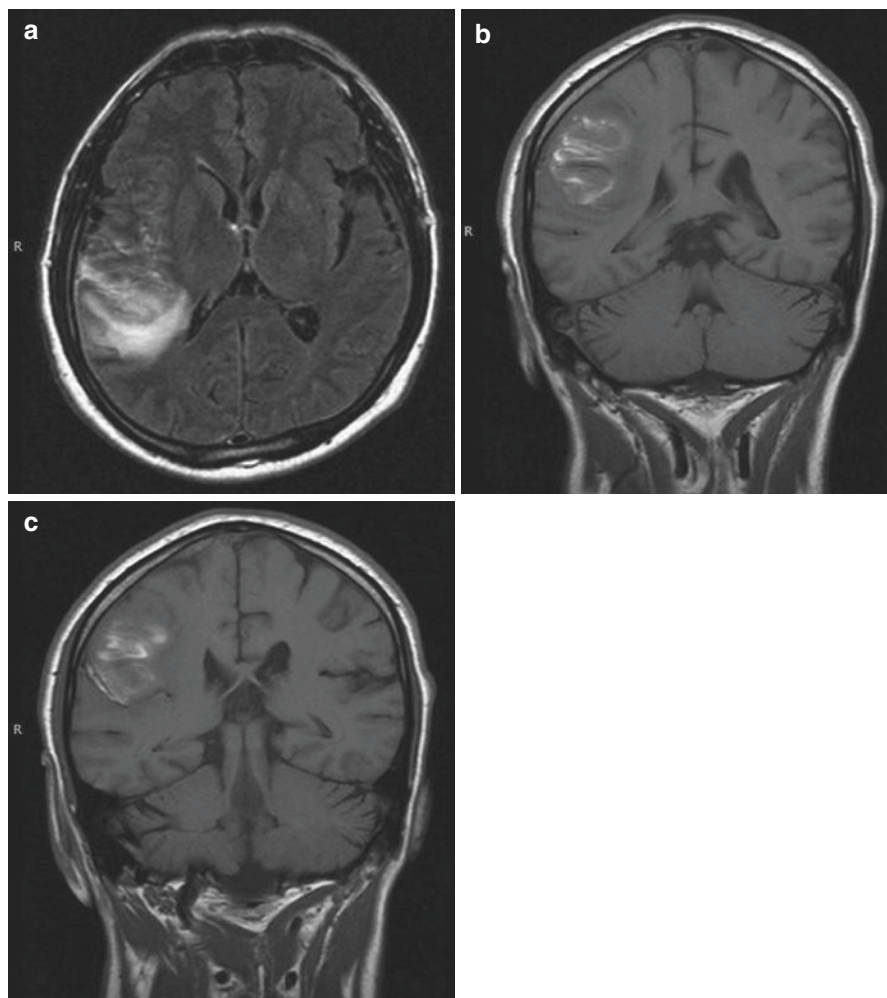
(a) T2 weighted axial MRI scan at the same level showing heterogeneous T2 signal alteration edema of the parietal white matter, and some mass effect, and (b) coronal T1 weighted scan showing the same lesion, with T1 shortening inferiorly due to hemosiderin deposition (implying that the hemorrhage had occurred at various times in evolution)
